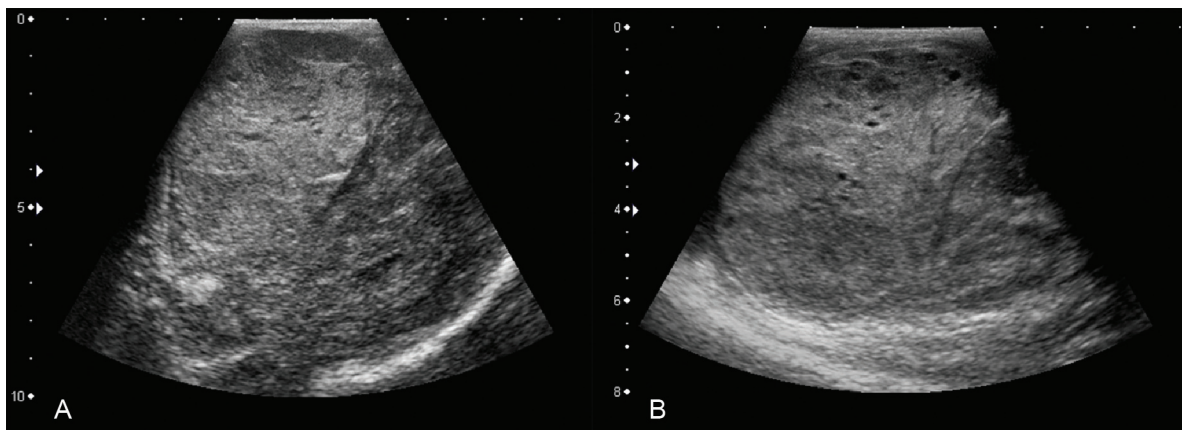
A and B – Ultrasonography of the left scrotal sac showing a heterogeneous mass with some scattered cystic areas (notably in B).
